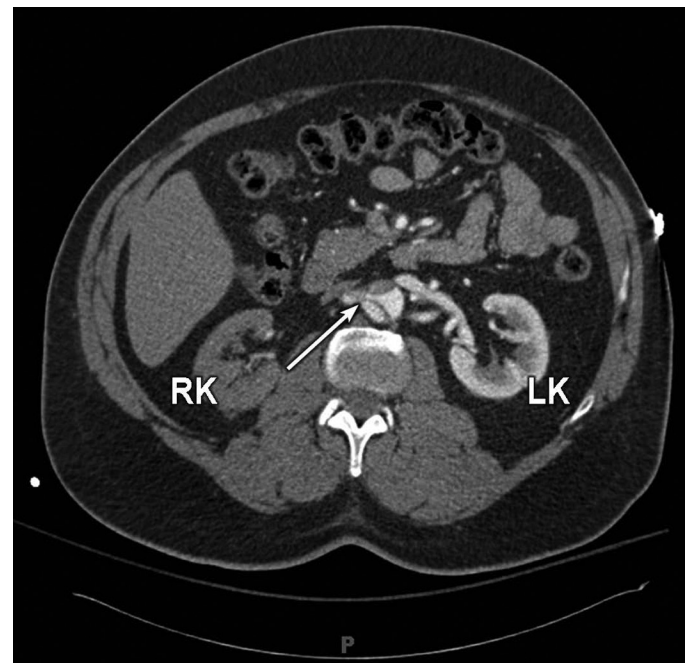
Contrast-enhanced CT scan demonstrating malperfusion of the right kidney (RK) because of acute aortic dissection. The dissection flap involves the right renal artery (arrow). The left kidney (LK) demonstrates normal perfusion and opacification, whereas the RK has poor perfusion with contrast material, consistent with malperfusion.
